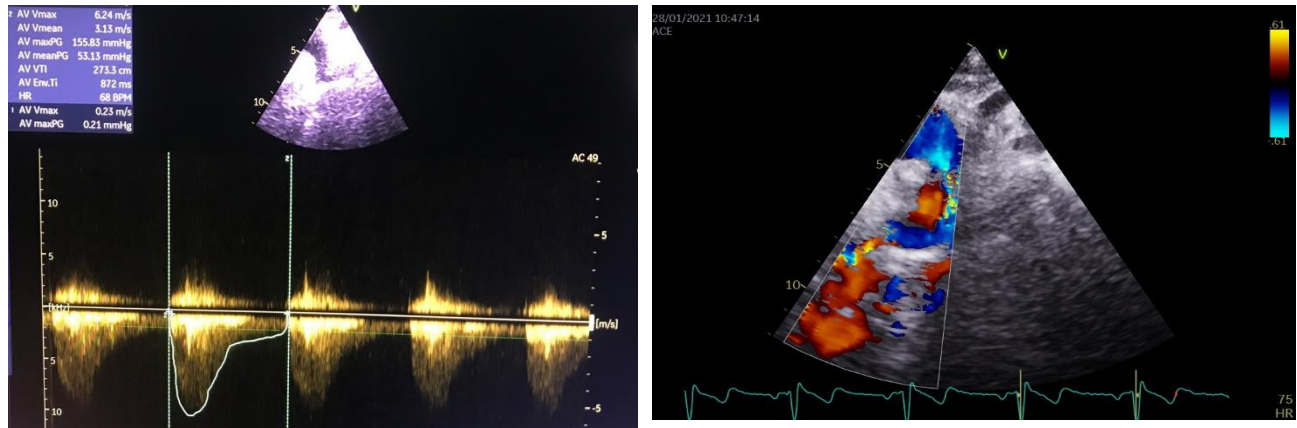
Transthoracic echocardiography findings for aortic coarctation
